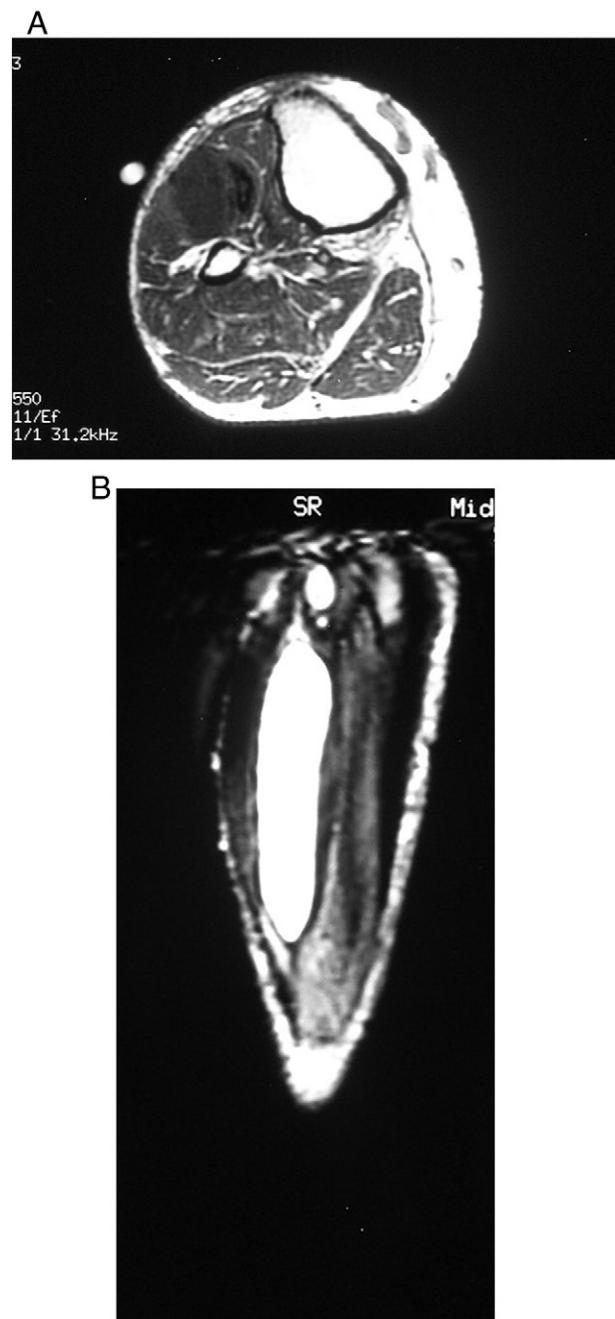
A: T1 weighted MRI (axial image) showing a cystic lesion on the antero-lateral aspect of the proximal tibia B: T2 weighted MRI (coronal image) showing the cystic lesion in the lower leg.
